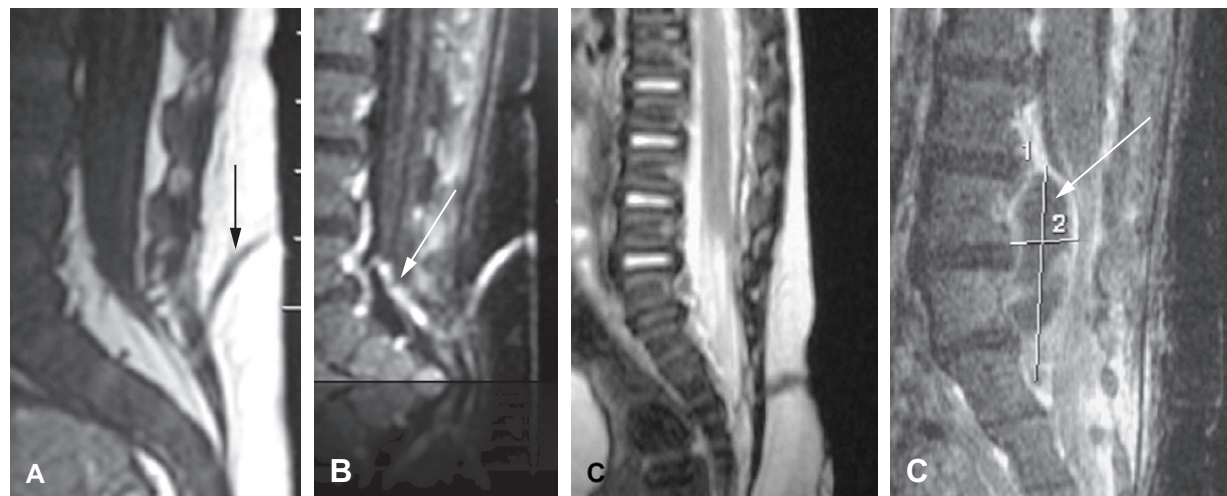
Dermal sinus. (A) Sagittal T1-weighted MR. Visualization of the extradural sinus (arrow). (B) Sagittal T1-weighted MR after contrast injection and fat saturation (FATSAT GADO). Same patient. This sequence enhances the extradural sinus and allows the intradural tract (arrow) to be seen. (C) Sagittal T2-weighted MR. Neglected dermal sinus. (D) Sagittal T1-weighted MR with gadolinium. Same patient. Intradural abscess (arrow).
